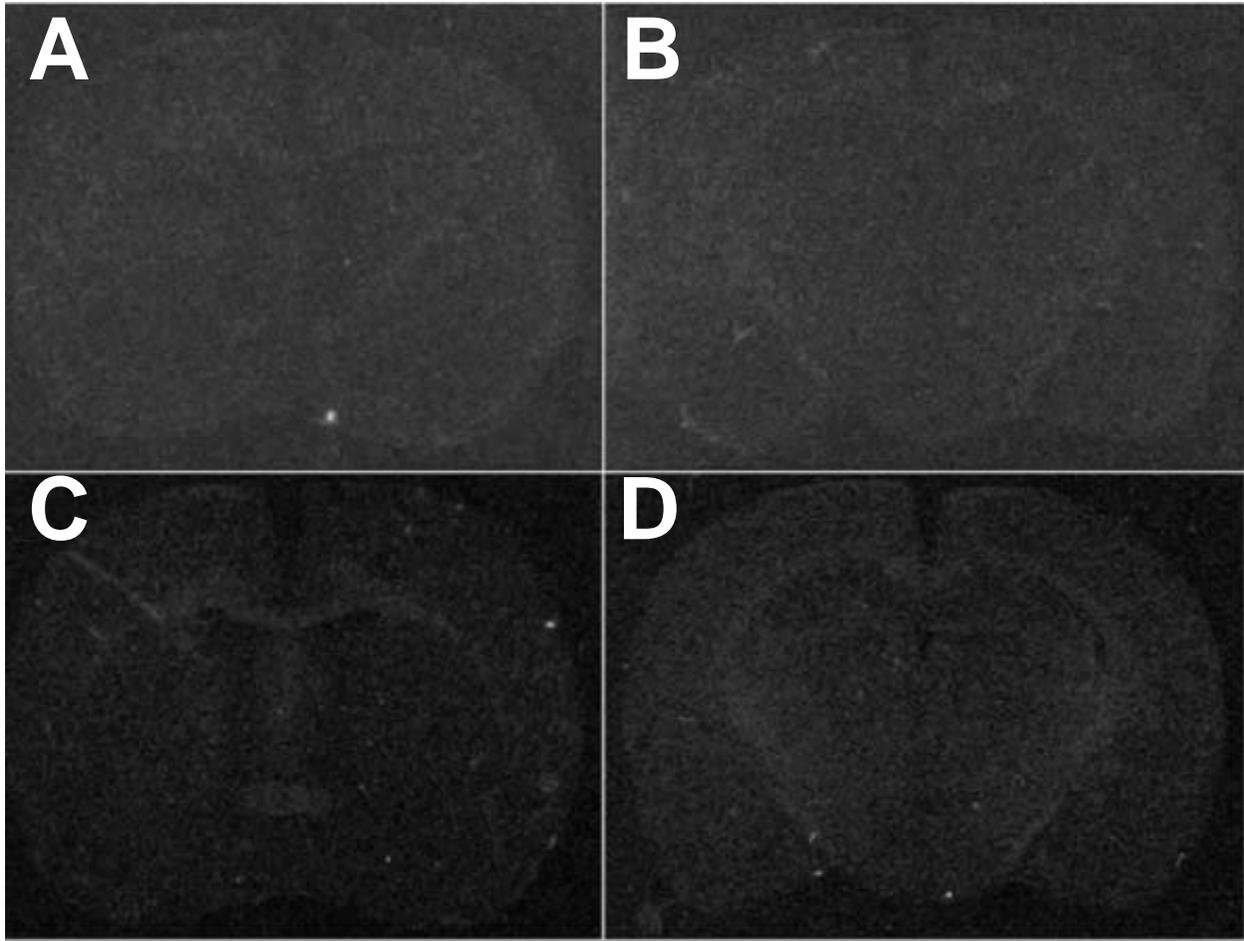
Representative x-ray images of brain sections treated with sense riboprobes. Sections treated with (A,B) N/OFQ sense strands and (C,D) NOP receptor sense strands did not display any specific signal, and background levels were comparable to those of antisense-treated sections.
